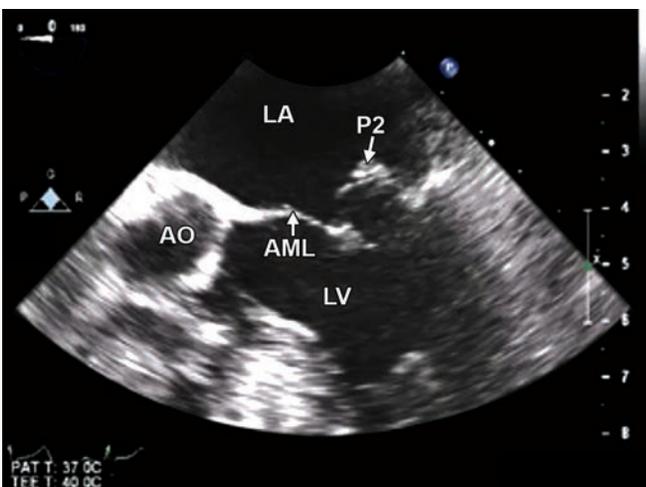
Two-dimensional transesophageal echocardiogram at the mid-esophageal level demonstrating prolapse of the P2 scallop of the posterior mitral leaflet.
